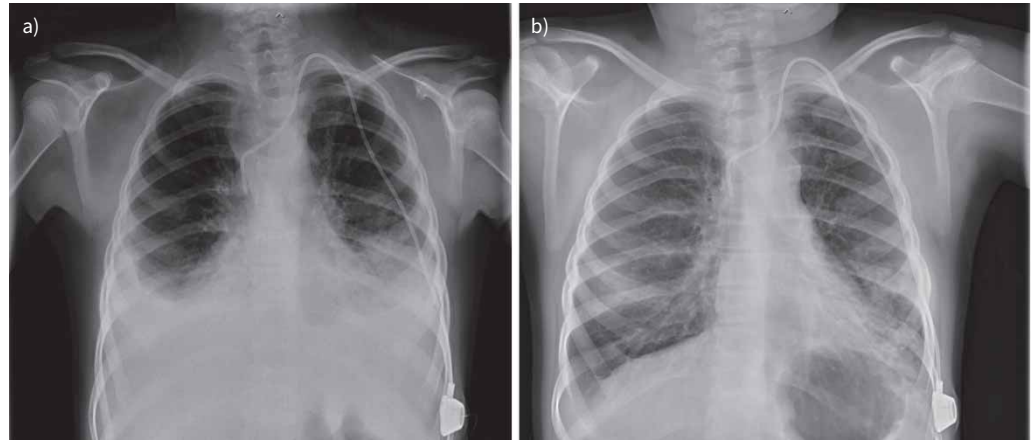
a) Chest radiography demonstrating bilateral pleural effusions on day 7 of admission for exacerbation of bronchiectasis in a patient with CF. b) Chest radiography with marked reduction in pleural fluid following 12 weeks of antifungal treatment.
